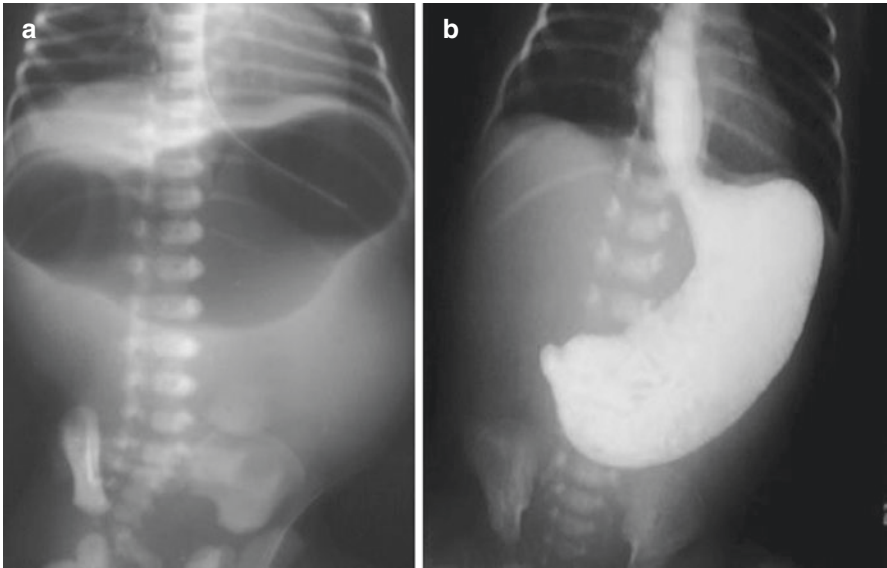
(a and b) Plain abdominal radiograph showing a single large gastric bubble with no distal gas in a patient with congenital pyloric atresia
